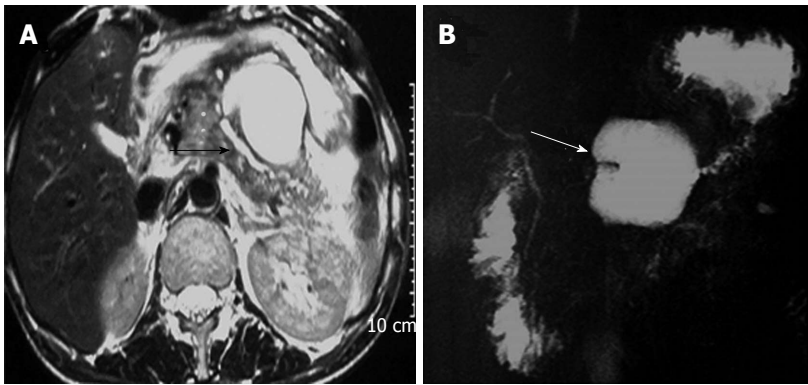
Magnetic resonance images. T2 weighted axial image (A) and magnetic resonance cholangiopancreatography (B) in a case of traumatic pancreatitis show heterogeneous signal intensity of pancreas with peripancreatic stranding. Main pancreatic duct is dilated in the body and tail region (black arrow). A lobulated pseudopancreatic cyst is seen in lesser sac anterior aspect of body of pancreas (white arrow) demonstrated in magnetic resonance cholangiopancreatography.
